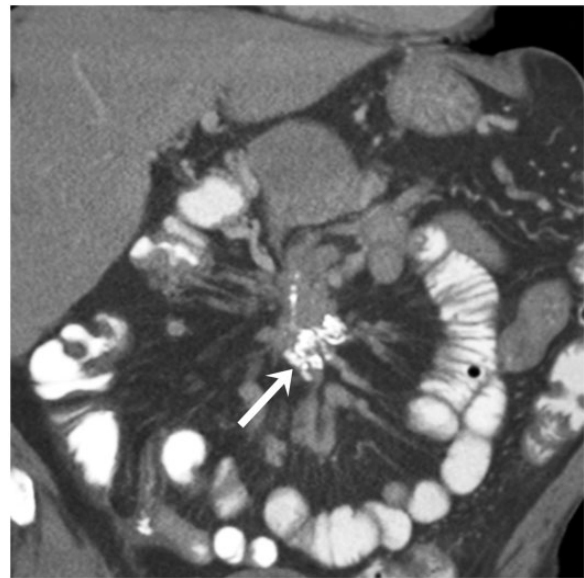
A 69-year-old man with well-differentiated neuroendocrine carcinoma of the small bowel. Coronal contrast-enhanced CT image demonstrates the typical appearance of this tumor, with a calcified mesenteric mass (arrow) and desmoplastic reaction displacing the small bowel loops peripherally.
